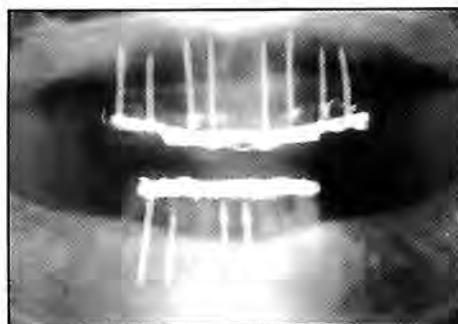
Panoramic radiograph of the maxillary and mandibular TIs.
